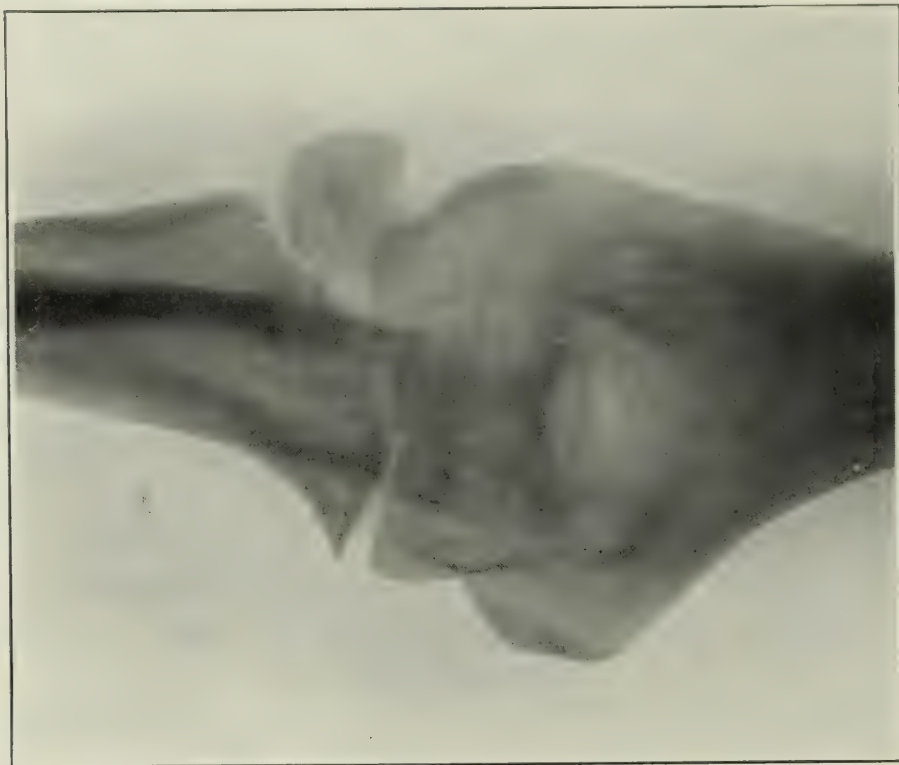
D. W. Pres. Hosp. Hist. No. 54360. Antero-posterior radiograph of elbow joint showing fragment consisting of three fourths of radial head rotated through 180° , so that the articular surface points downward.
